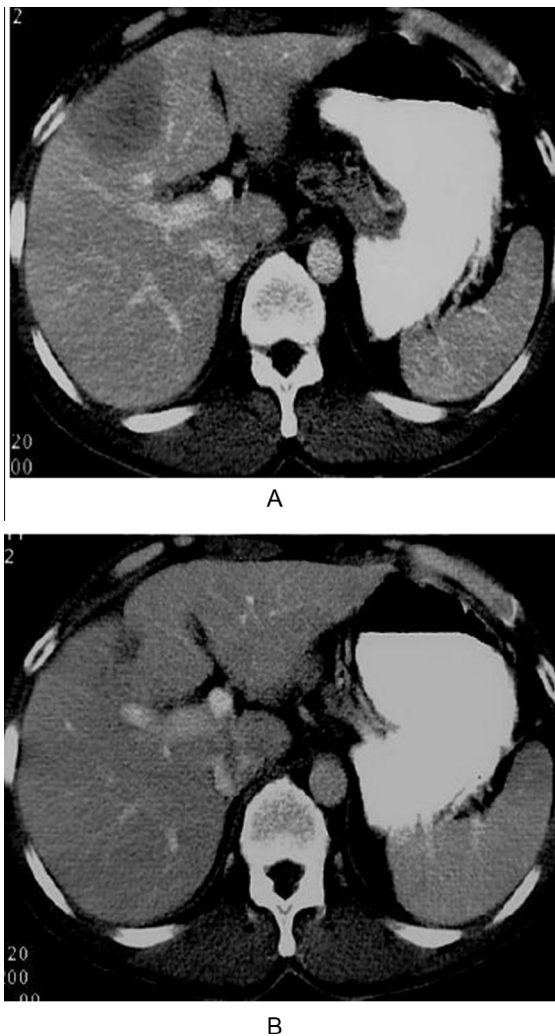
57-Years-old female with HD received 6 cycles of CHOP. Triphasic abdominal CT scan was done. (A) (Portal phase) before starting chemotherapy shows a non-enhancing focal lesion of segment IV, biopsy revealed HD. (B) (Portal phase) obtained 6 months after starting of chemotherapy shows capsular retraction of the liver. The size of the hepatic mass is markedly decreased.
